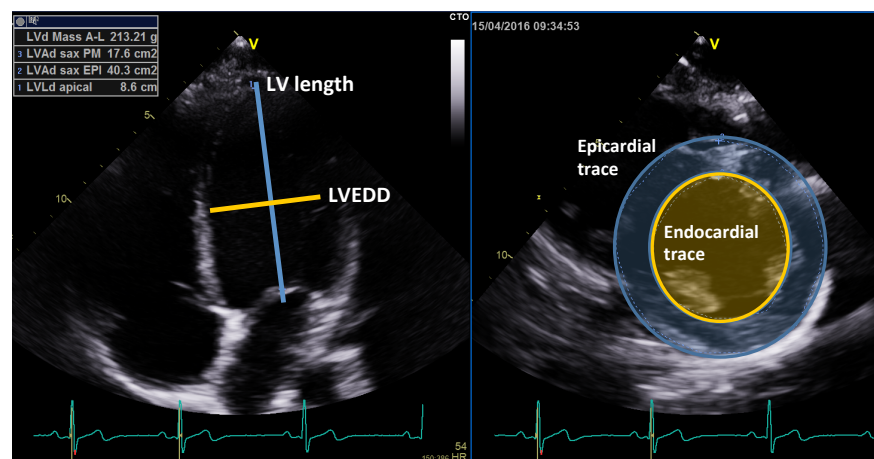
Left ventricular (LV) mass measurement using the area-length method. LV length from an apical 4-chamber (left panel) image at end-diastole and mean wall thickness from tracing the cross sectional area of the epicardial and endocardial border on a parasternal short axis view at the level of the papillary muscle at end-diastole (right panel). LV length and LV end-diastolic diameter (LVEDD) are used to calculate sphericity index.
